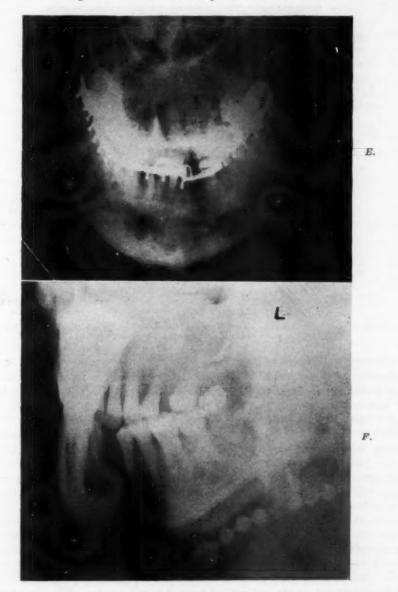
A, Occlusal roentgenograms showing overriding ends of fracture segment.
